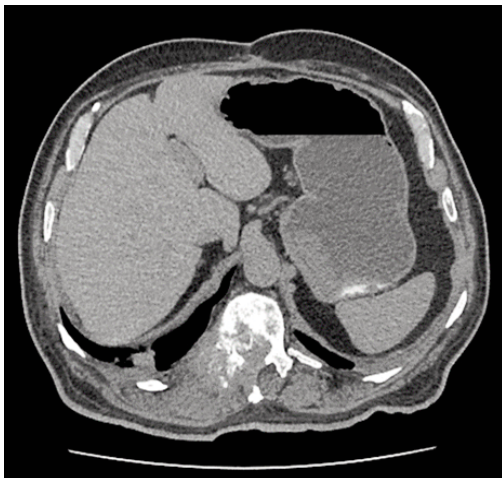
An axial view of the CT abdomen with contrast demonstrating destruction of D11 and D12 vertebrae involving the posterior element, along with a 37mm x 25mm sessile hypodense area covering the posterior wall of the antrum.
